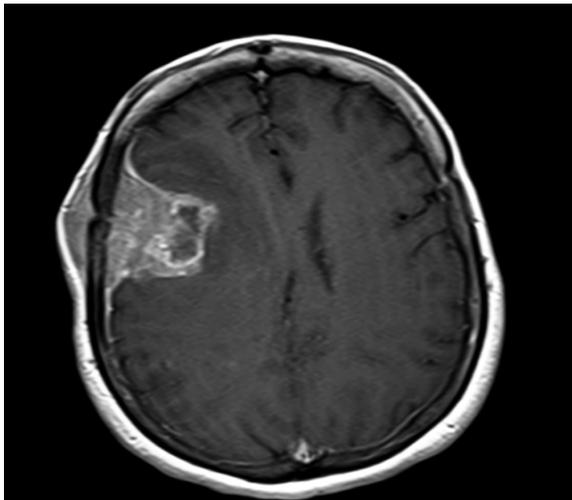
Axial slice using magnetic resonance imaging demonstrating the right parietal intracranial metastases.
